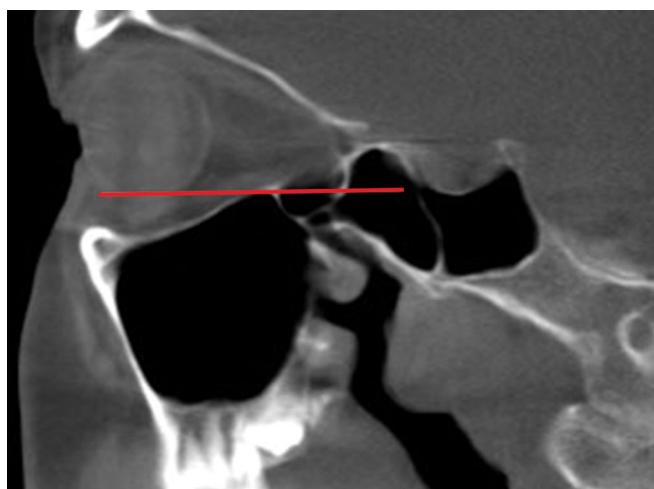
Computed tomography of orbital floor never being higher than sphenoid roof.
